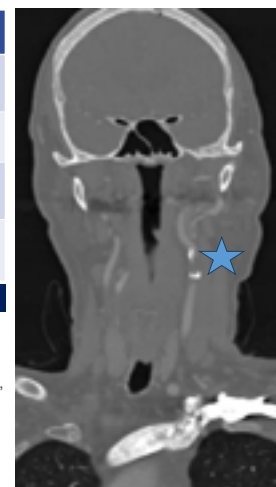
CTA of Neck 90% occlusion of left internal carotid artery (ICA) (blue star)
